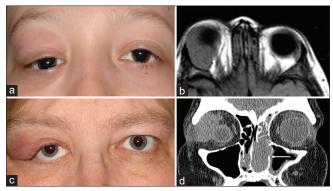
Orbital presentation of Rosai-Dorfman disease. (a) External photograph of 10-year-old male (case #4) with right upper eyelid mass, showing blepharoptosis and inferolateral globe displacement. (b) Axial T1 magnetic resonance imaging showing large, well-defined mass in the lacrimal gland region of the orbit. (c) External photograph of 52-year-old woman (case #5), showing erythematous right upper eyelid mass, blepharoptosis, and mild proptosis. (d) Coronal orbital computed tomography scan showing a large homogeneous lesion in lacrimal gland region of the orbit. White arrow shows involvement in para nasal sinuses
